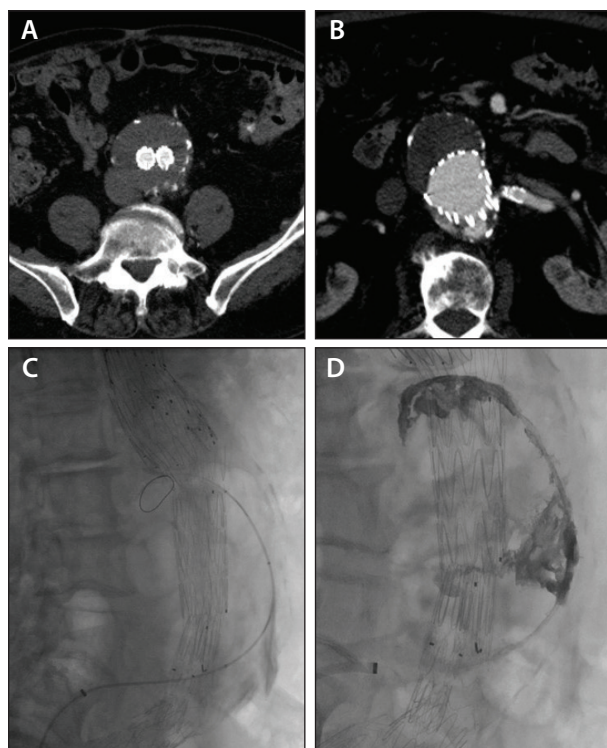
A male patient in his early 90s after FEVAR with type II endoleak and interval growth of aneurysm sac. CTA demonstrated the IVC in contact with the excluded aneurysm sac and adjacent to the L4 lumbar arteries involved in the endoleak (A). There was also a superior component involving the L1 lumbar arteries (B). Transcaval access was obtained with coaxial NaviCross catheters advanced into the sac (C). Postembolization imaging demonstrating Onyx liquid embolic in the endoleak nidus (D).
